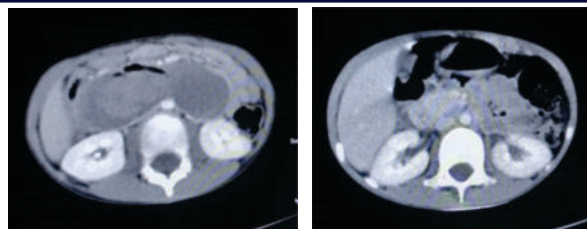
and 1B: (1A) Contrast Computed Tomography of the abdomen showing a Large retroperitoneal collection between the SMA and Aorta, compressing the IVC posteriorly and small bowel loops anteriorly, with a hypodense central focus. (1B) Post-operative Contrast Computed Tomography of the abdomen suggestive of minimal residual collection
